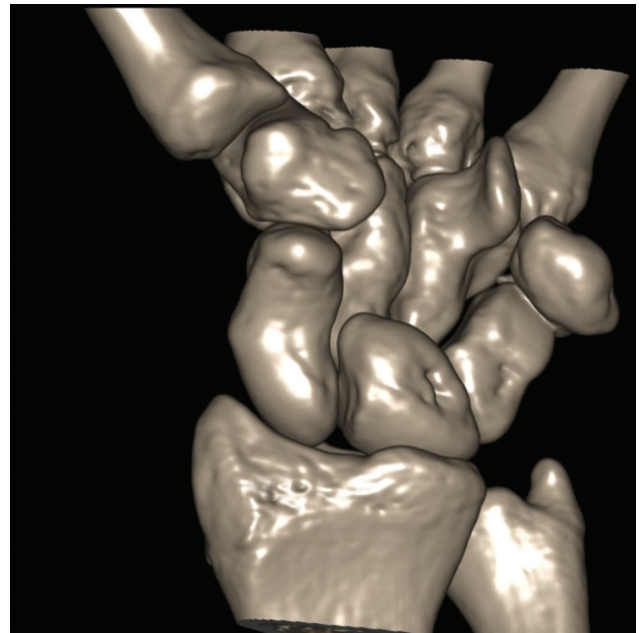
Computed tomography scan (with three-dimensional reconstruction) showing pisiform dislocation and no other concomitant lesions.
